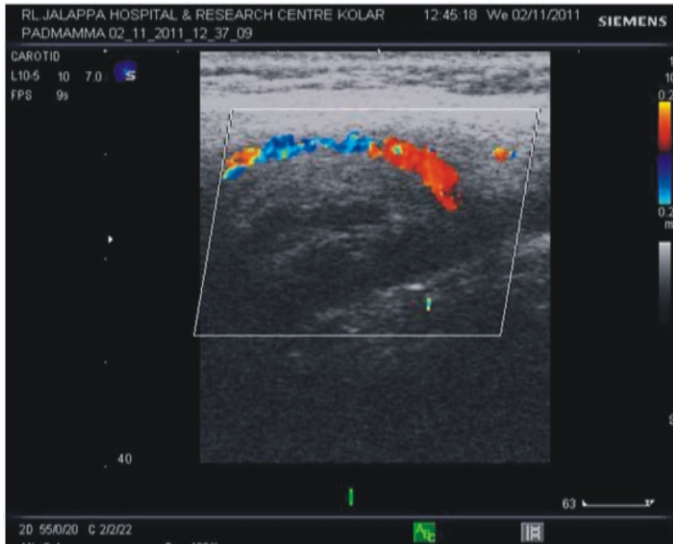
Doppler study of the carotid showing increase flow velocity of the internal carotid artery suggestive of extra luminal compression by carotid body tumour.
